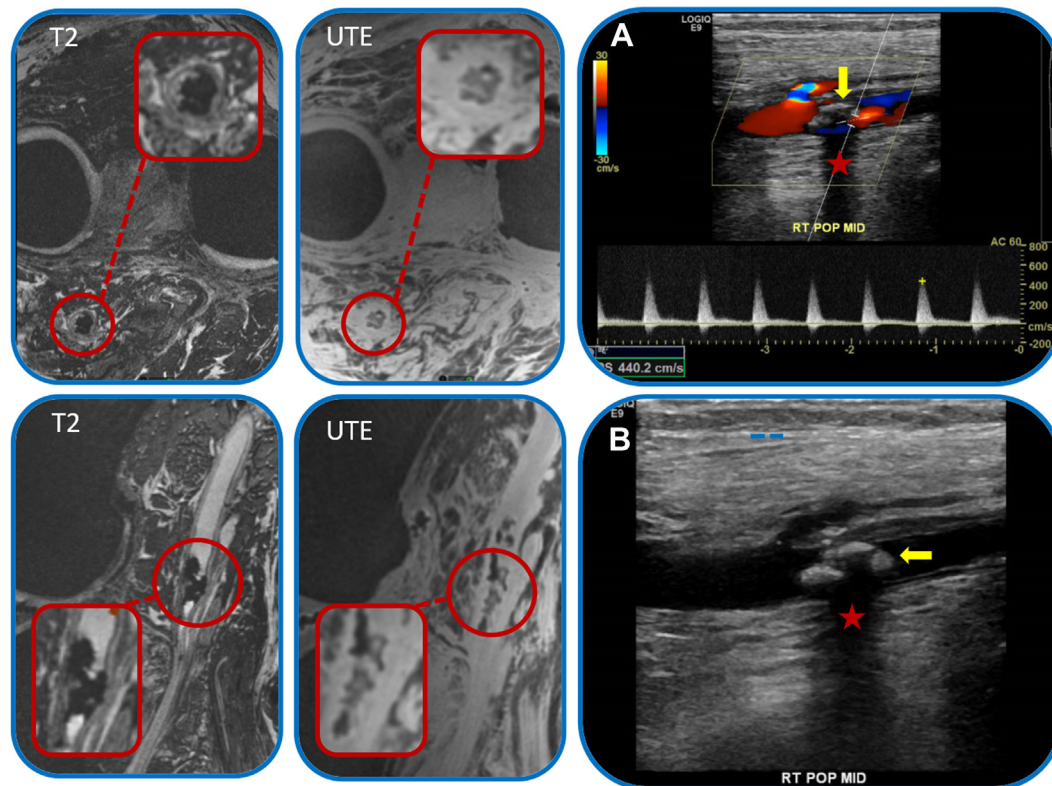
Comparison of 7T magnetic resonance imaging (MRI) and color duplex ultrasound examination of a middle popliteal artery segment plaque. A,B. Color duplex ultrasound images showing an echogenic, solid, nodular, calcified plaque (*yellow arrow*) with shadowing artifact (*red star*). Doppler ultrasound (A) showing significant hemodynamic stenosis (peak systolic velocity, 440 m/s). On color duplex ultrasound, detailed plaque morphology can be determined only to a very limited extent. In contrast, 7T T2 and ultrashort echo time (UTE) images of the same plaque show explicit plaque structure with speckled calcium as a signal void in an iso-intense dense collagen matrix. MID, Middle segment; POP, popliteal artery; RT, right.
